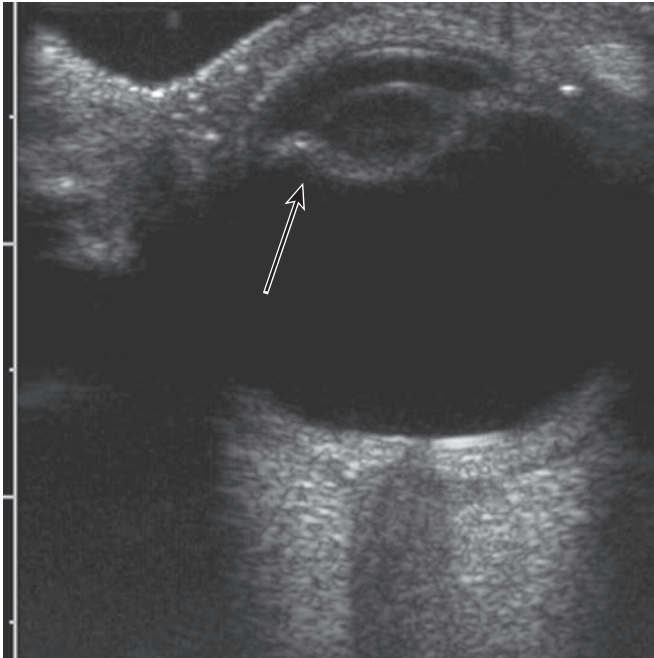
Cataract. Transverse ultrasound of the left eye shows increased echogenicity of the lens (arrow) indicating a cataract.
